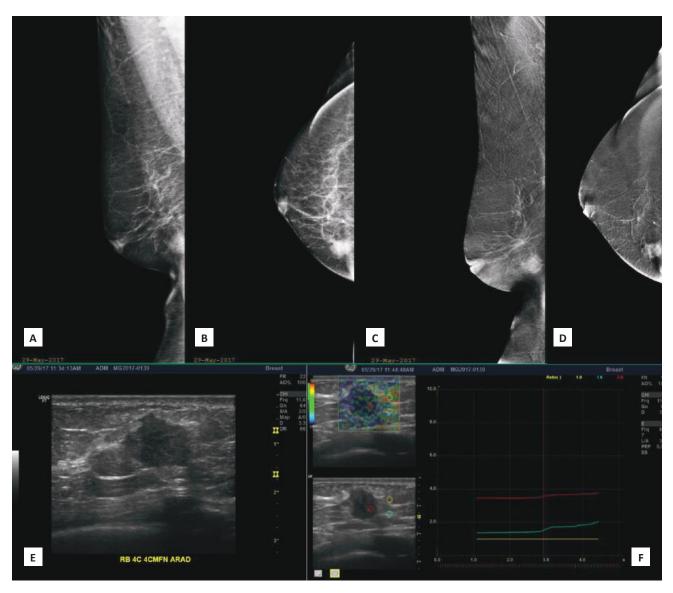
A 63-year-old post-menopausal female with a newly palpable right breast mass with no family history of breast cancer. (A, B) Low-energy (LE) Mediolateral Oblique (MLO) and Craniocaudal (CC) views of the right breast, which has a fatty breast composition, showing an irregular mass of high density at the lower inner quadrant. (C, D) Subtracted images (SI) in MLO and CC projections show avid enhancement of the right lower inner quadrant breast mass. No other abnormal enhancing lesions are demonstrated. The background parenchyma also shows no enhancement. (E) Ultrasound correlate of the said mass shows an irregular markedly hypoechoic solid mass. (F) Elastography (which is a measure of tissue stiffness) shows the mass to be significantly hard compared to the adjacent fat and glandular tissues.
